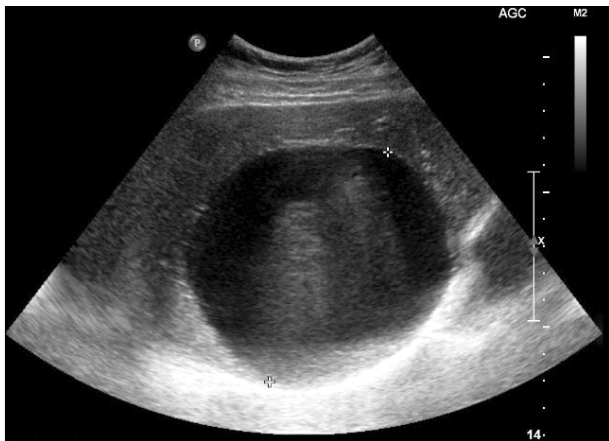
Abdominal ultrasound shows a well-defined hypoechoic lesion.
